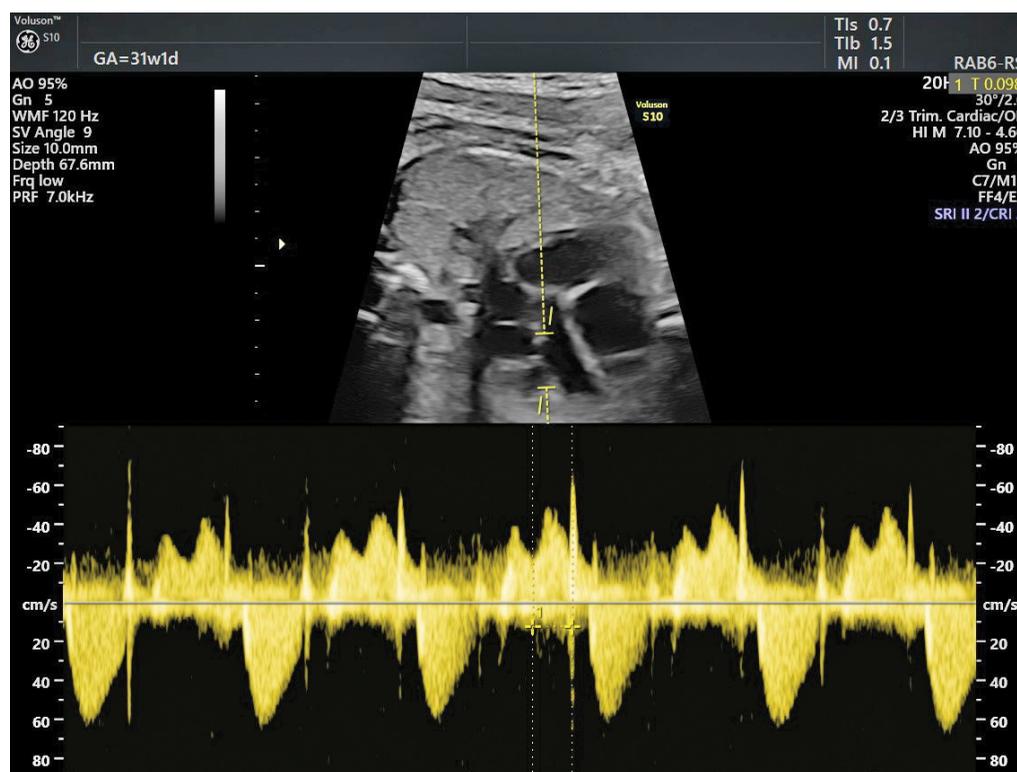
Fetal ultrasound power-Doppler measuring the PR interval as part of a strategy of detecting grade 1 fetal AV block
